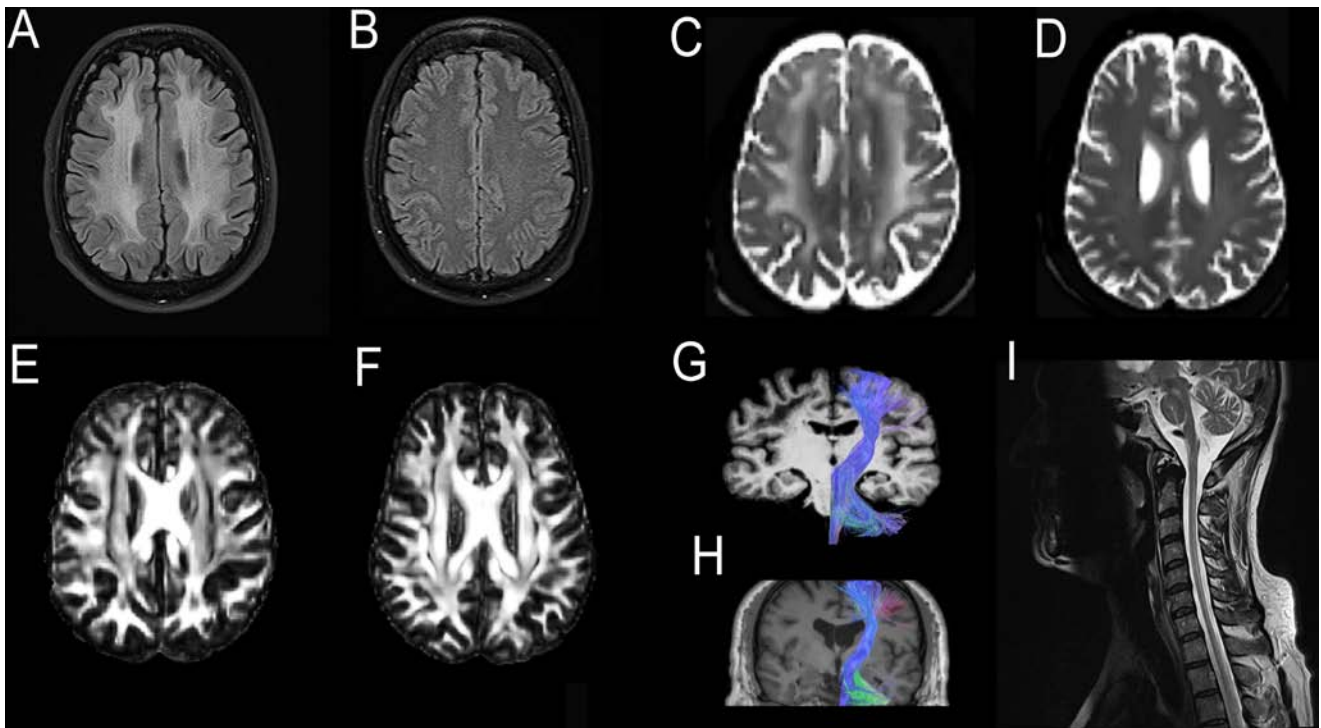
MRI FLAIR (patient, A, and control, B), HARDI ADC (patient, C, and control, D), HARDI FA (patient, E and control, F), HARDI fiber tractography of corticospinal tract (patient, G, and control, H), and MRI sagittal T2 of the cervical spine of the patient (I). Abbreviations: Apparent diffusion coefficient (ADC); Fluid Attenuated Inversion Recovery (FLAIR); Fractional anisotropy (FA); High angular resolution diffusion MR imaging (HARDI).
